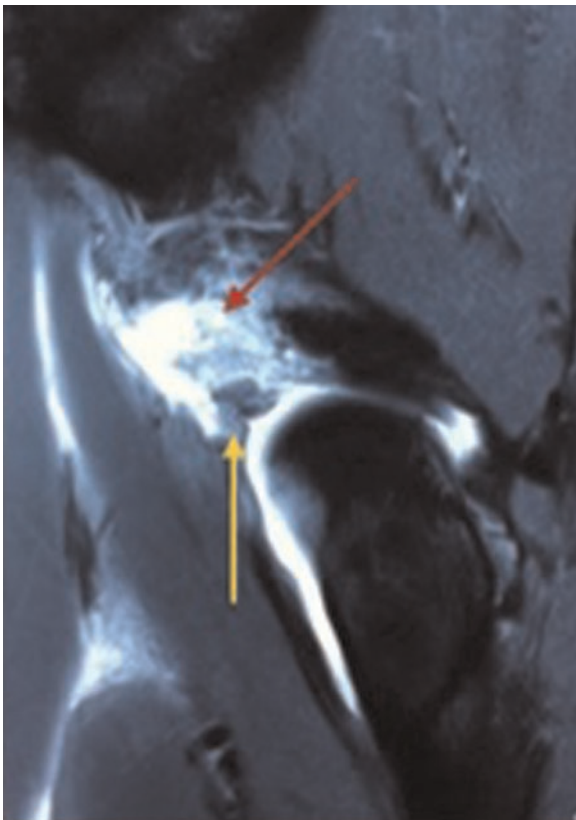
Sagittal T2 MRI scan of the left hip; the red arrow demonstrates significant oedema at the level of the AIIS; the yellow arrow shows the avulsed tendon of the dhRF with minimal retraction.
